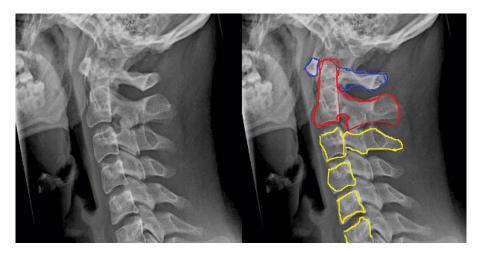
A lateral x-ray of the cervical spine, with an annotated view at right. In this annotation, C1 is outlined in blue, C2 in red (showing the projection of the odontoid into C1), and the lower cervical vertebrae in yellow. (Courtesy of Wikimedia.org)
